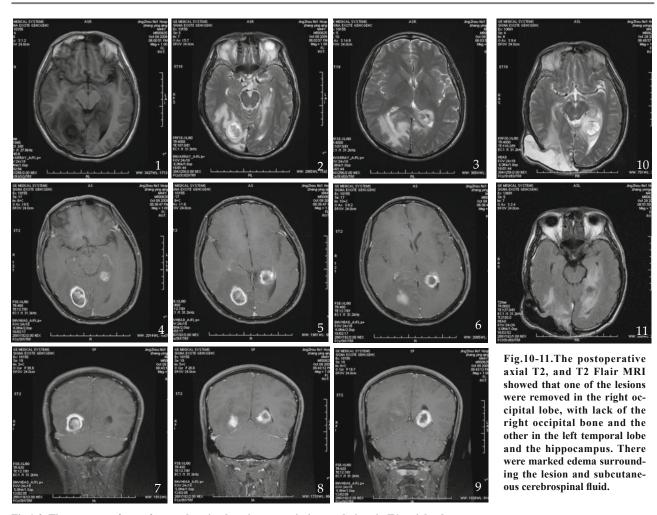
The presence of two of non-enhancing hypointense or isointense lesions in T1-weighted sequences (Fig.1) and hyperintense in T2-weighted sequences (Fig.2,3), located in the both occipital lobes and the area between left temporal and hippocampus, with the marked edema surround them, the contrast MRI(Fig. 4-9) revealed 2-3 obivious ring-shaped masses.
